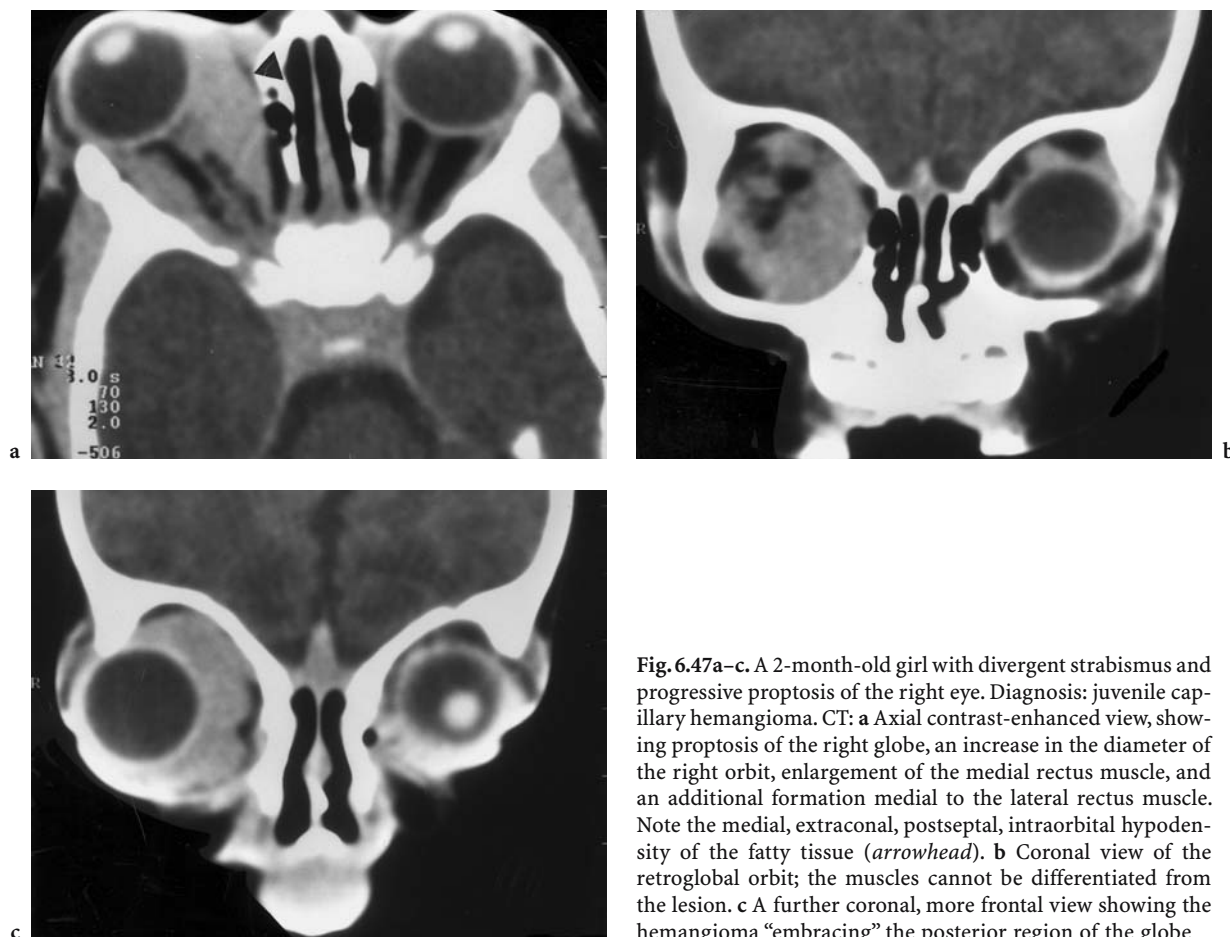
A 2-month-old girl with divergent strabismus and progressive proptosis of the right eye. Diagnosis: juvenile capillary hemangioma. CT: a Axial contrast-enhanced view, showing proptosis of the right globe, an increase in the diameter of the right orbit, enlargement of the medial rectus muscle, and an additional formation medial to the lateral rectus muscle. Note the medial, extraconal, postseptal, intraorbital hypodensity of the fatty tissue (*arrowhead*). b Coronal view of the retroglobal orbit; the muscles cannot be differentiated from the lesion. c A further coronal, more frontal view showing the hemangioma “embracing” the posterior region of the globe
